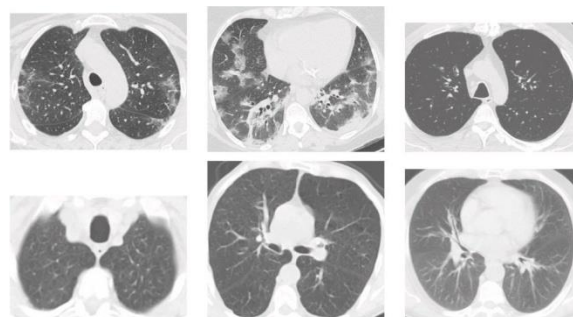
Examples of CT images that are: positive for COVID-19(top) and non-COVID-19(bottom)
